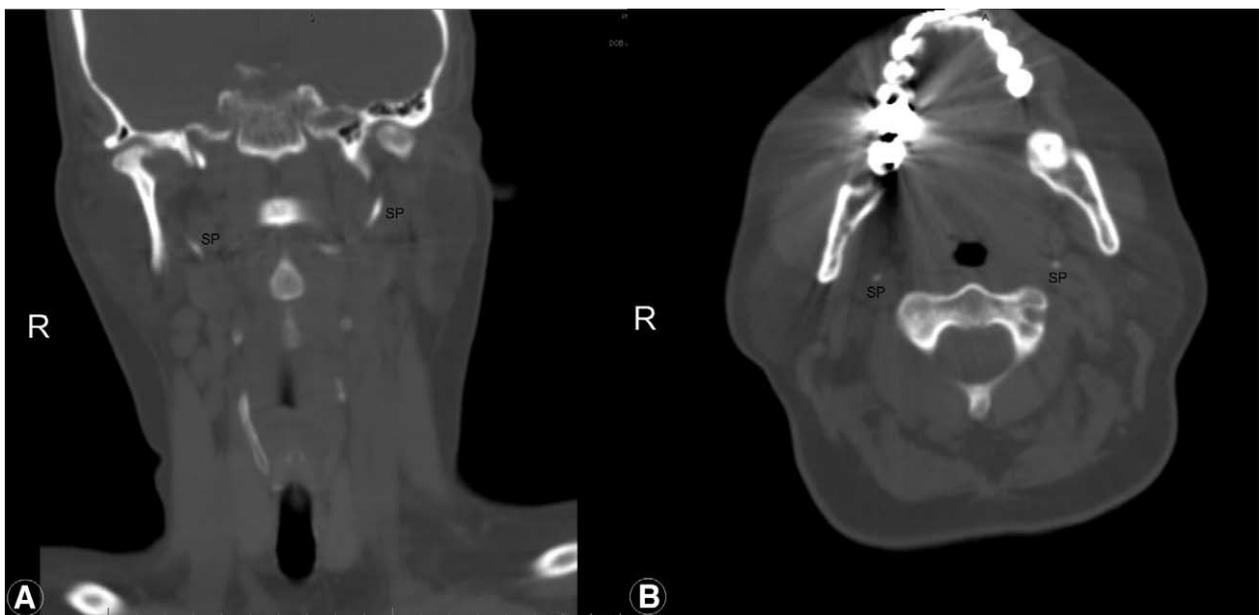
MRI imaging of bilateral elongated styloid processes, (A) coronal section and (B) Axial section. SP, styloid process.
